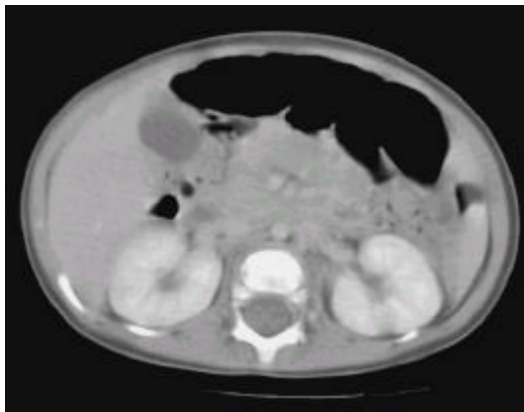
Abdominal CT shows that multiple low attenuated lesion with peripheral enhancement in the liver parenchyma and focal low attenuated small abscess pocket in inferior pole of left kidney has completely disappeared(Hospitalization day 31).
